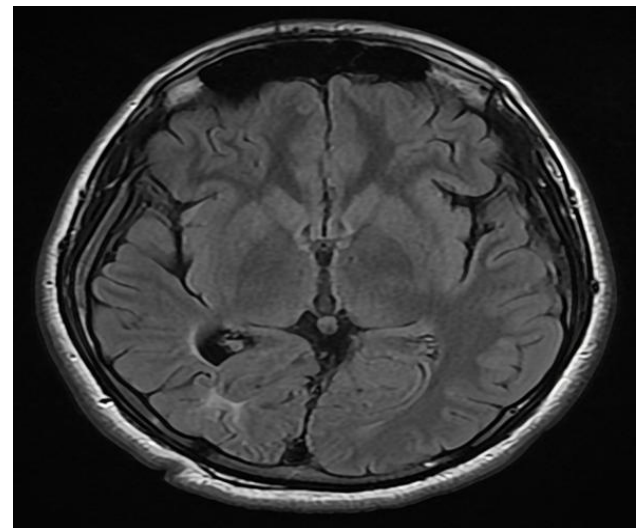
MRI scan T2-FLAIR axial view showing hyperintense subcortical white matter lesion involving the right occipital lobe associated with volume loss in the occipito-parietal lobe and posterior temporal region (Reprinted with permission of patient)
